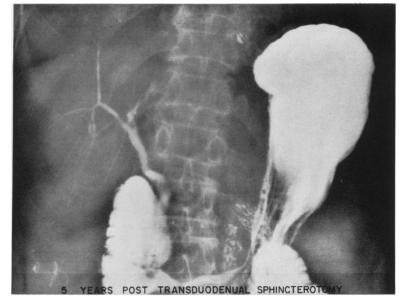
X-rays show reflux of barium 5 years after sphincterotomy for choledocholithiasis and terminal common duct obstruction
